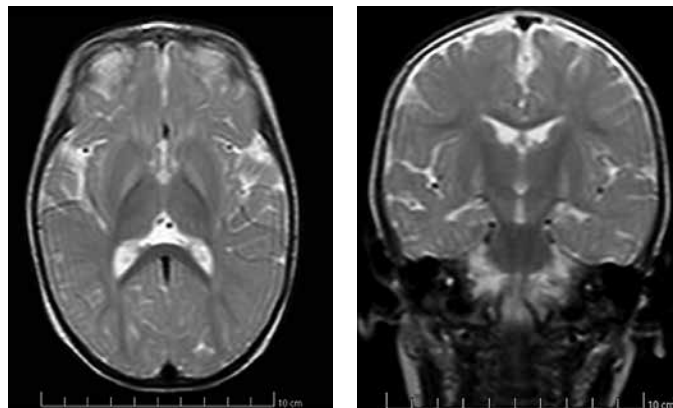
MRI T2-weighted sequence performed at 14 days of life with bilateral hyperintensity in the globus pallidus (arrows), confirming the diagnosis of chronic bilirubin-induced encephalopathy (kernicterus).
